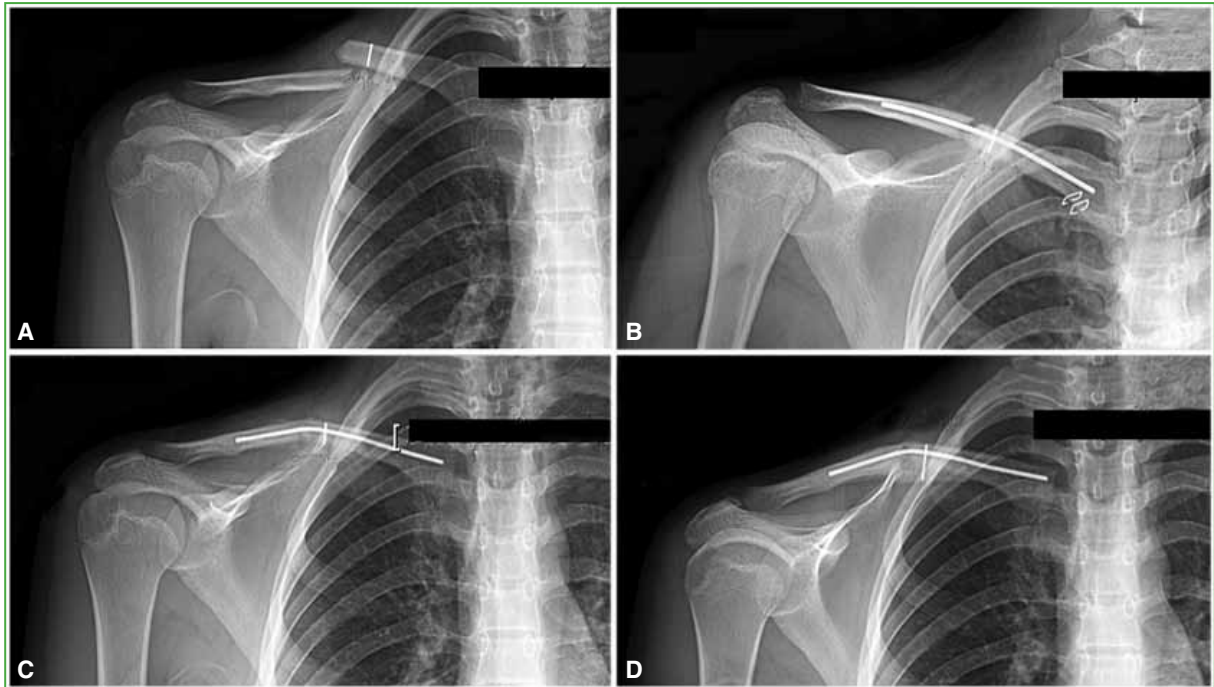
AP radiographs of the right clavicle. A. Simple midshaft fracture in a 14-year-old girl. B. Immediate post-op (note staples from single medial approach). C. Nine weeks: union signs without periosteal reaction, but nail angulation. D. One year: advanced adaptive remodeling with mature compact bone formation (predominantly inferior, compression side) and completed union.
